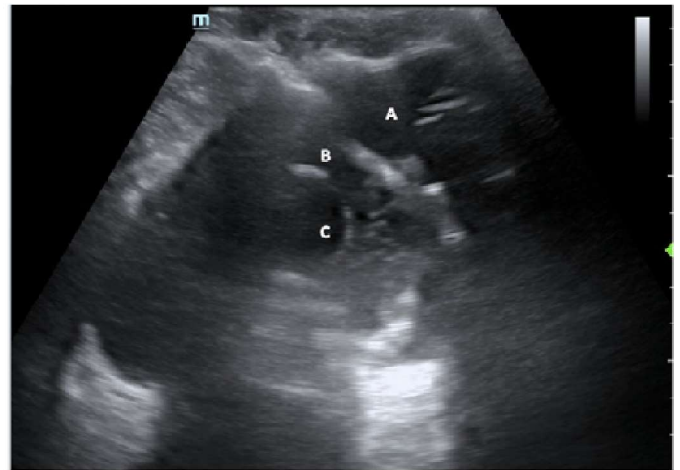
Ultrasound of the suprapubic area in transverse view obtained with a curvilinear transducer A. The saline reservoir drains into the cylinders which are implanted in the corpus cavernosum of the penis. B. Bladder C. Foley catheter balloon.
